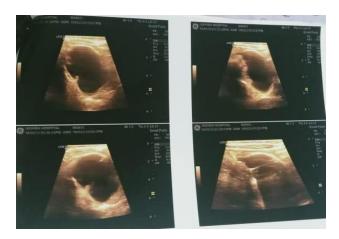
Ultrasonography showing gastrointestinal cyst.
